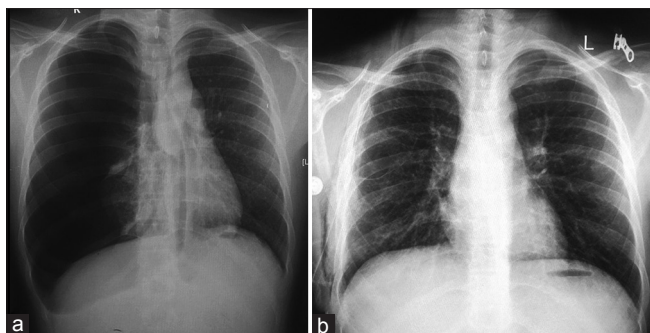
(a) Chest radiograph demonstrating large right-sided pneumothorax with mediastinal shift and (b) complete expansion of lung after tube thoracostomy
